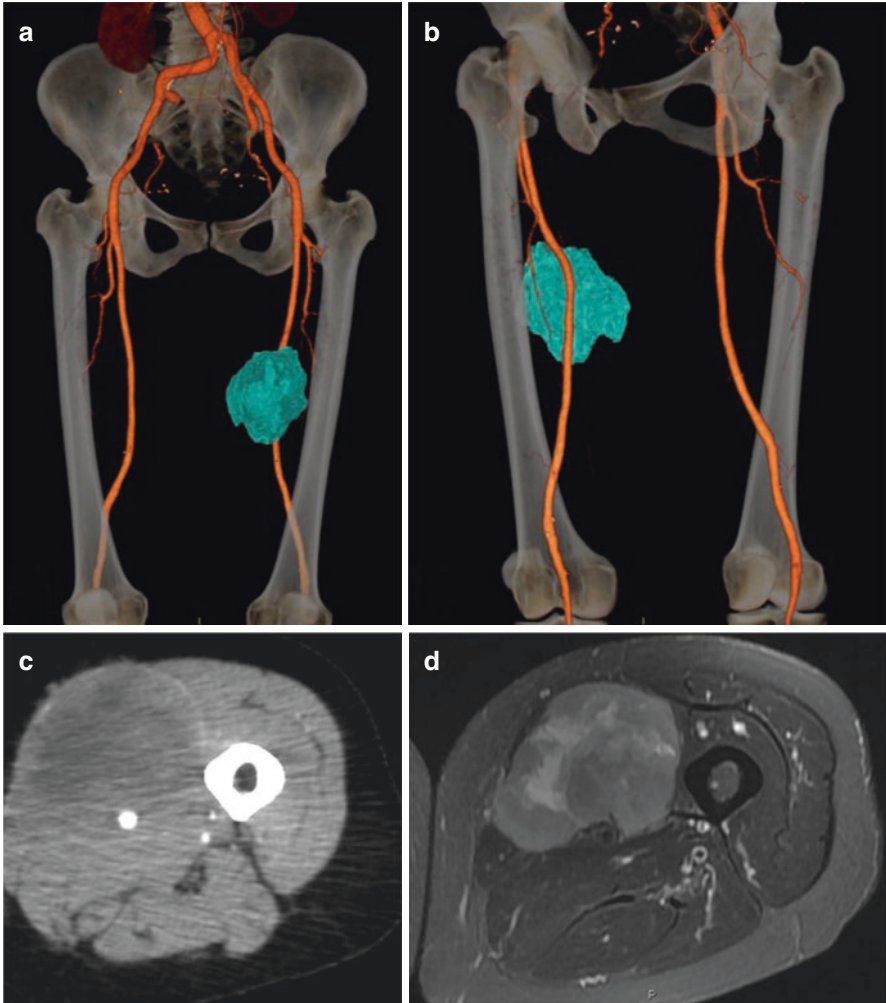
3D volume rendering of a CTA showing a high-grade spindle-cell sarcoma in the left thigh and its relationship with the femoral artery (a, b). Axial view of the same CTA demonstrates tumor vessel contact of approximately 180°. (c) MR axial T2-weighted image with fat saturation (d) characterize tumor limits more precisely than the CTA due to high tissue contrast of the method
